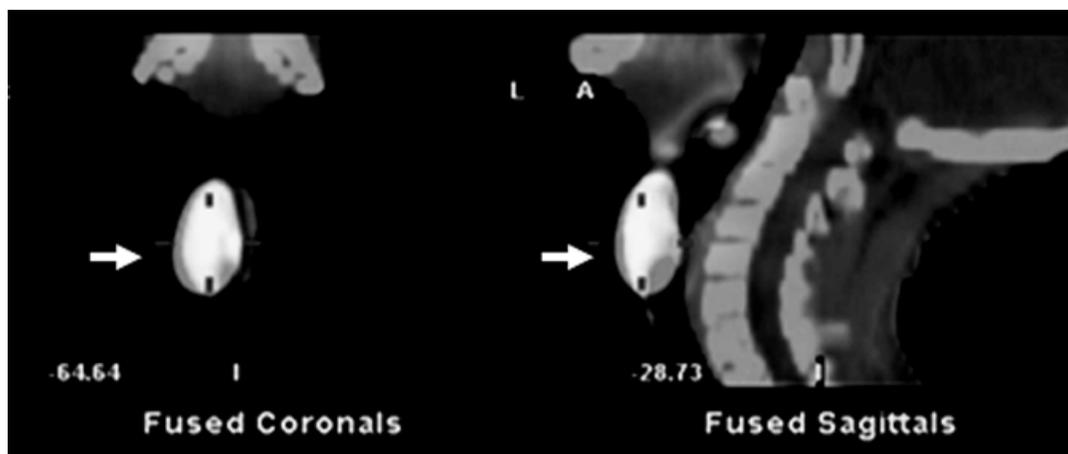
$^{99m}\text{TcO}_4^-$  SPECT CT coronal and sagittal sections showing  $^{99m}\text{TcO}_4^-$  uptake in linear soft tissue on the right side of the midline (arrows).
